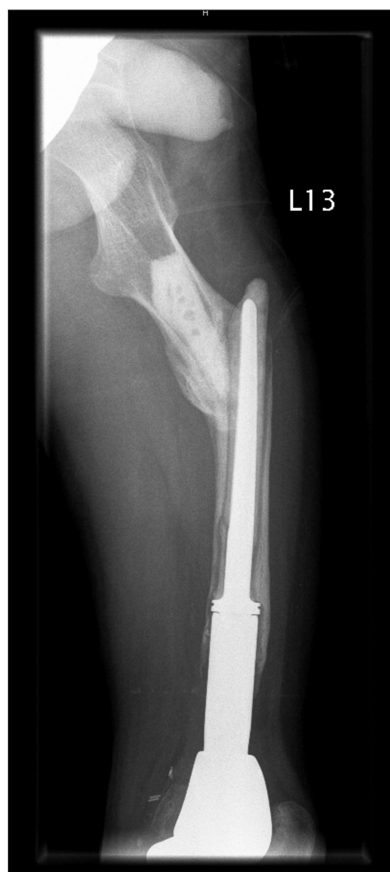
17-year-old boy with femoral osteosarcoma one month after implantation of endoprosthesis. X-ray: fracture of the femoral stump.
